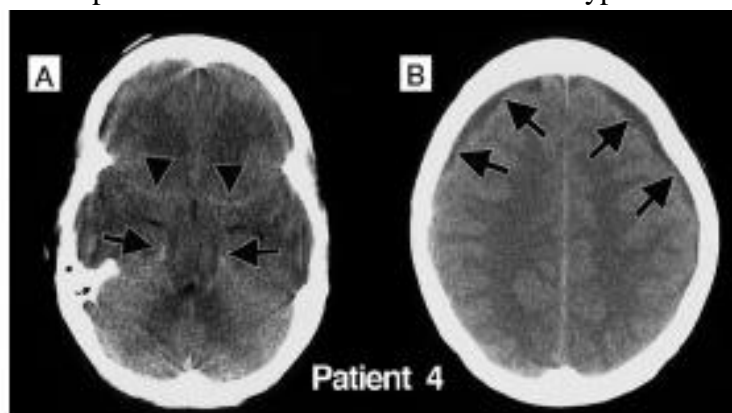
Nonenhanced CT of the brain shows increased attenuation along the tentorium cerebelli (A, arrows) and in the basilar cisterns/sylvian fissures (A, arrowheads), in addition to subdural fluid collections (B, arrows).
